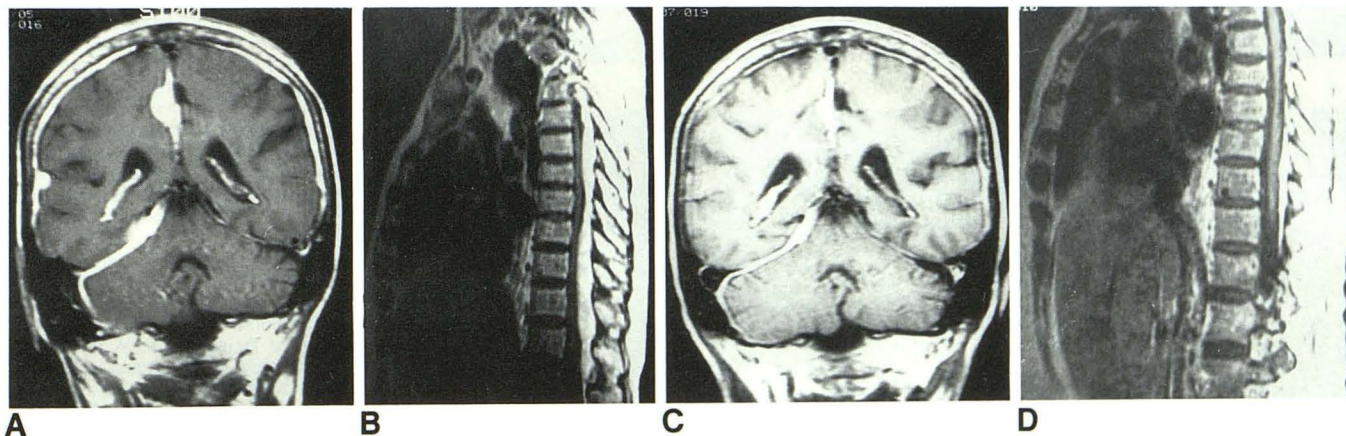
Gd-DTPA-enhanced MR images in CNS extramedullary hematopoiesis.
